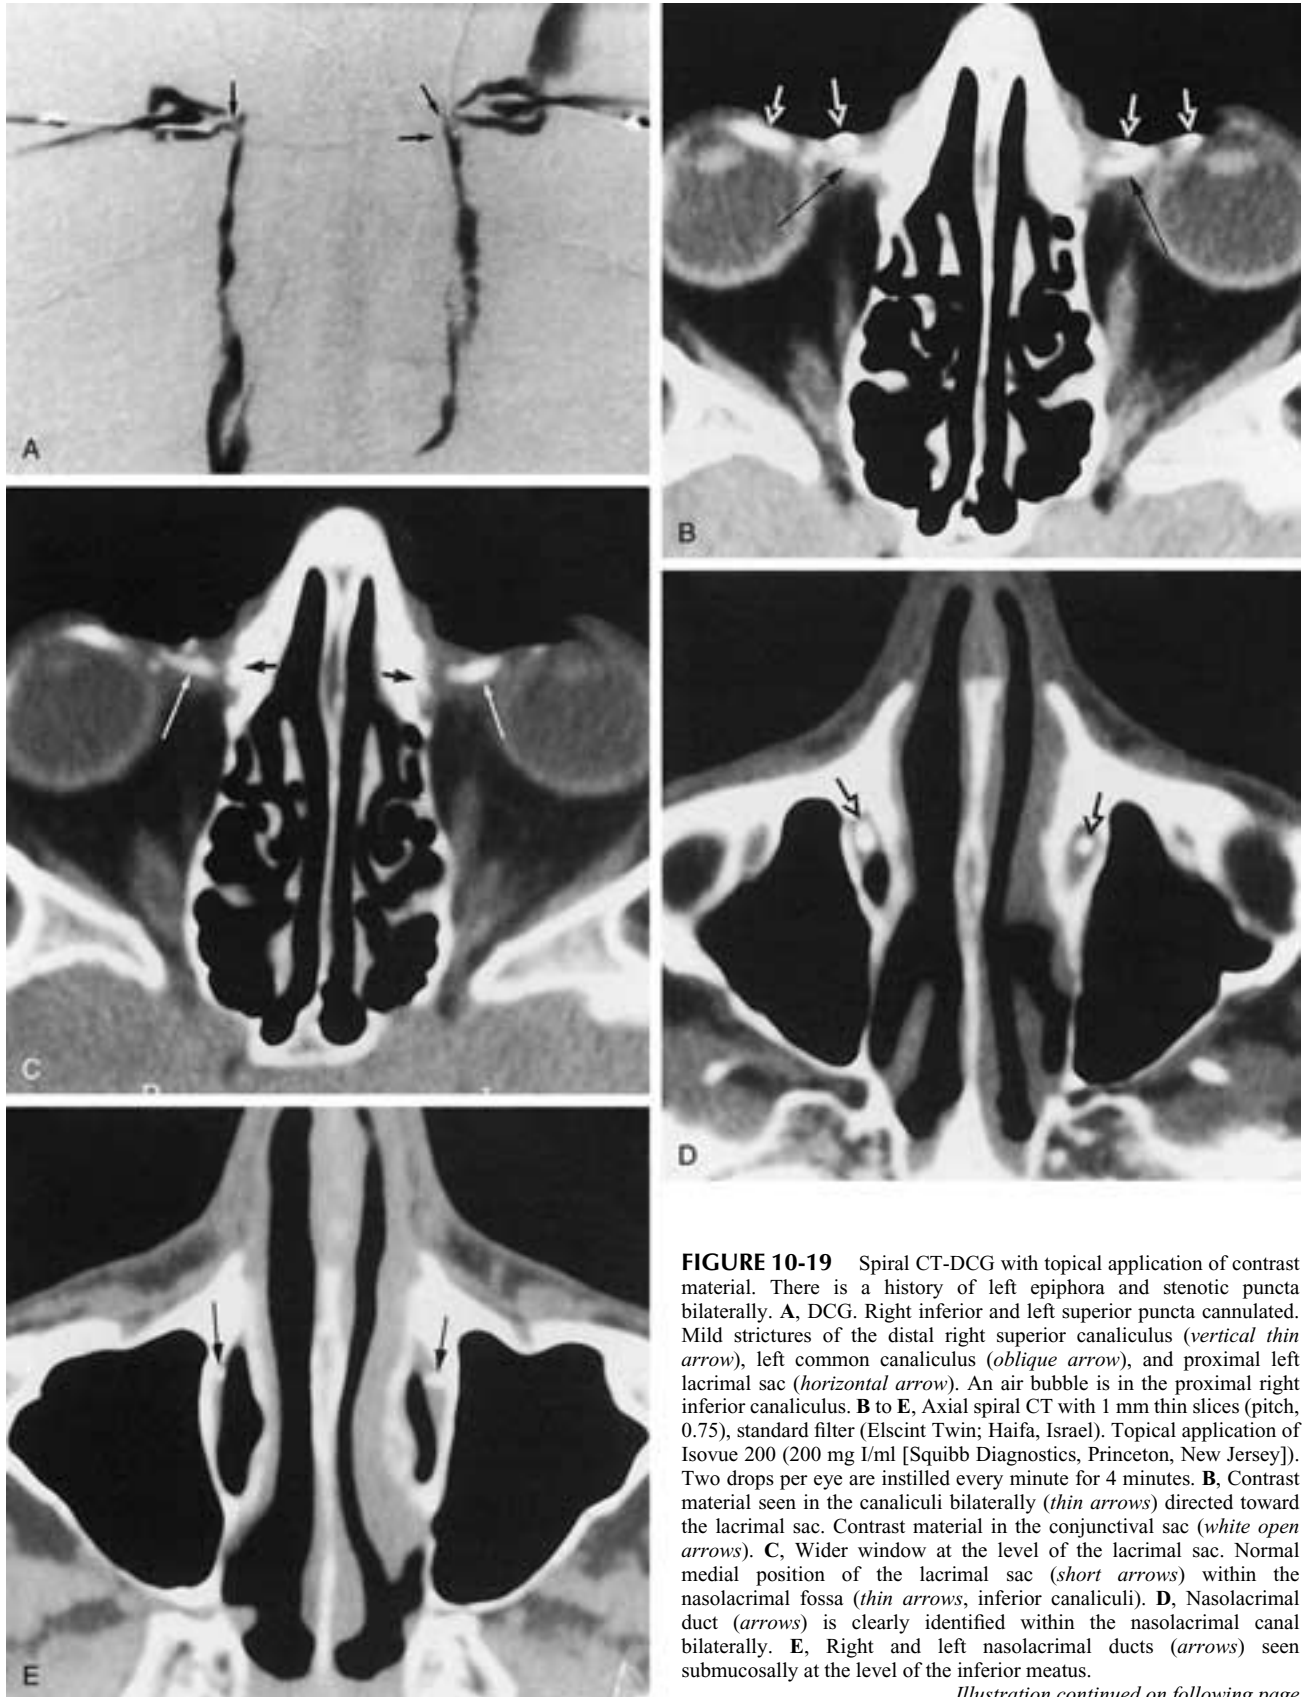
Spiral CT-DCG with topical application of contrast material. There is a history of left epiphora and stenotic puncta bilaterally. A, DCG. Right inferior and left superior puncta cannulated. Mild strictures of the distal right superior canaliculus (*vertical thin arrow*), left common canaliculus (*oblique arrow*), and proximal left lacrimal sac (*horizontal arrow*). An air bubble is in the proximal right inferior canaliculus. B to E, Axial spiral CT with 1 mm thin slices (pitch, 0.75), standard filter (Elscent Twin; Haifa, Israel). Topical application of Isovue 200 (200 mg I/ml [Squibb Diagnostics, Princeton, New Jersey]). Two drops per eye are instilled every minute for 4 minutes. B, Contrast material seen in the canaliculi bilaterally (*thin arrows*) directed toward the lacrimal sac. Contrast material in the conjunctival sac (*white open arrows*). C, Wider window at the level of the lacrimal sac. Normal medial position of the lacrimal sac (*short arrows*) within the nasolacrimal fossa (*thin arrows*, inferior canaliculi). D, Nasolacrimal duct (*arrows*) is clearly identified within the nasolacrimal canal bilaterally. E, Right and left nasolacrimal ducts (*arrows*) seen submucosally at the level of the inferior meatus.
